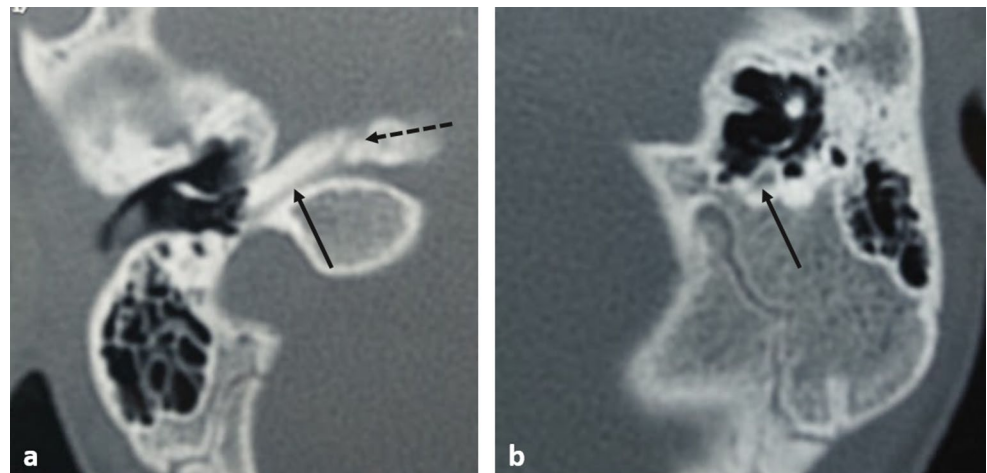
Temporal bone CT scan of patient5, axial slides showing: a: at the right side: a posterior course of the labyrinthine segment of the FN (black arrow), the greater petrosal nerve is represented by the dashed black arrow. b: at the left side, the only visualized portion is the mastoid segment (black arrow)
